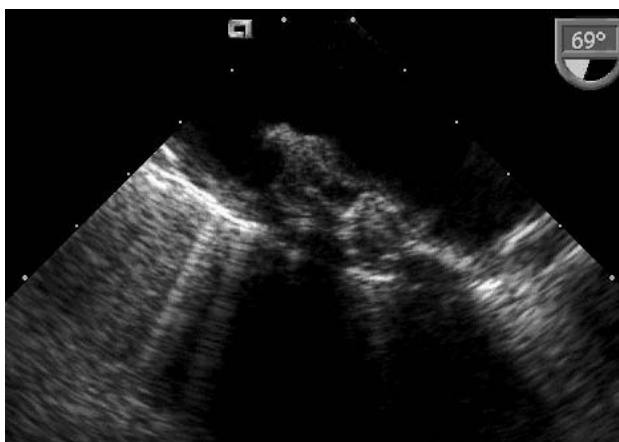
Transesophageal echocardiography of the thoracic aorta in a patient with complicated ulcerated aortic plaque.
